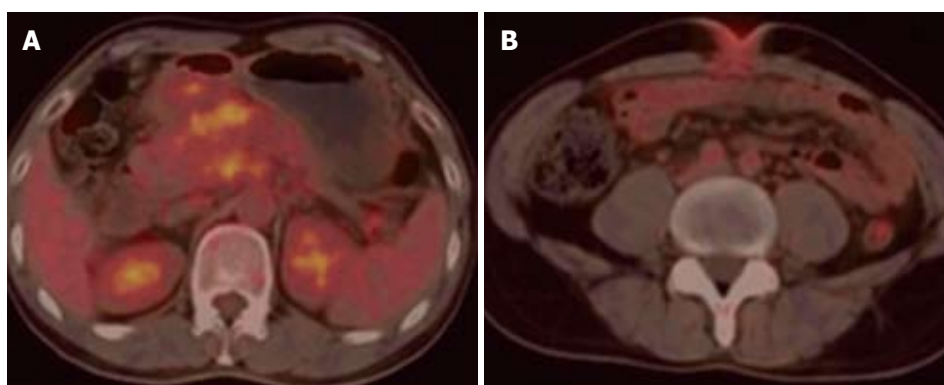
Positron emission tomography-computed tomography showed increased fludeoxyglucose uptake of tumors. A: Significant enhanced signal showing increased fludeoxyglucose (FDG) uptake at the site of pancreatic mass; B: Increased FDG uptake at the site of umbilical nodule.
